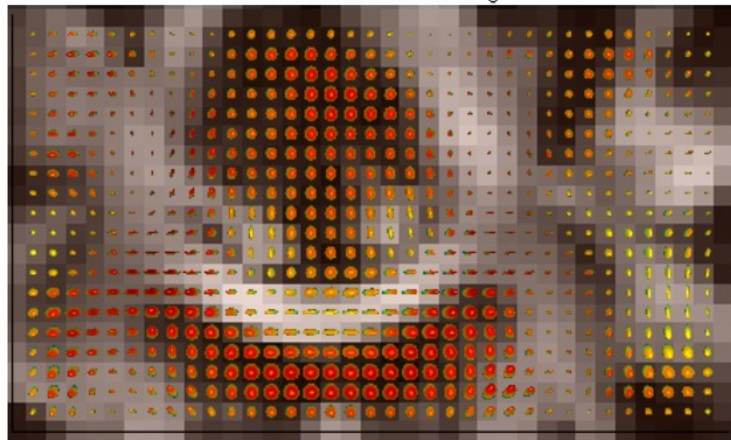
Feature enhancement experiment (with backward Ricci flow) using MRI data. Number of iterations  $n = 40$ .
